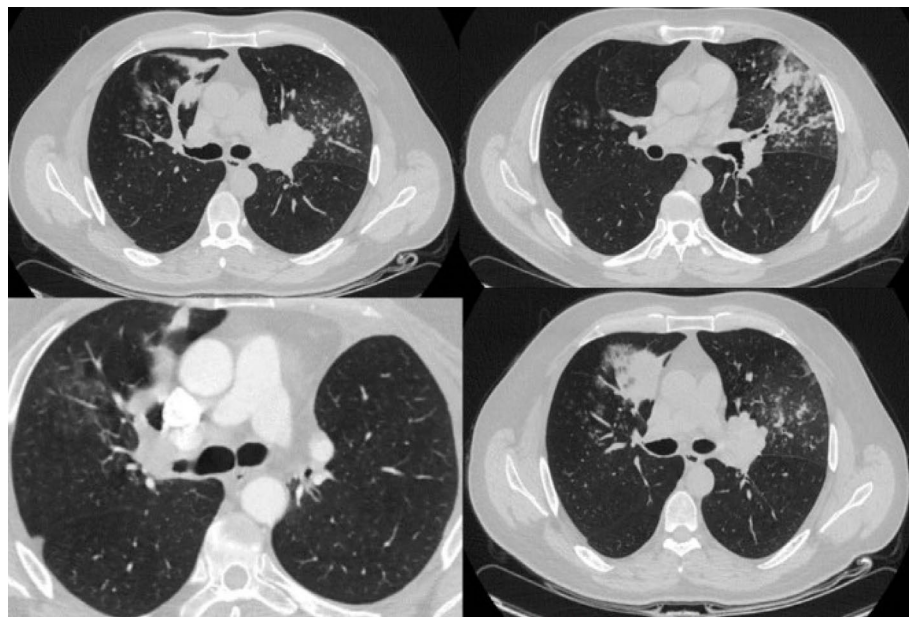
CT of TCO from 04/19/2018 before the start of treatment.
